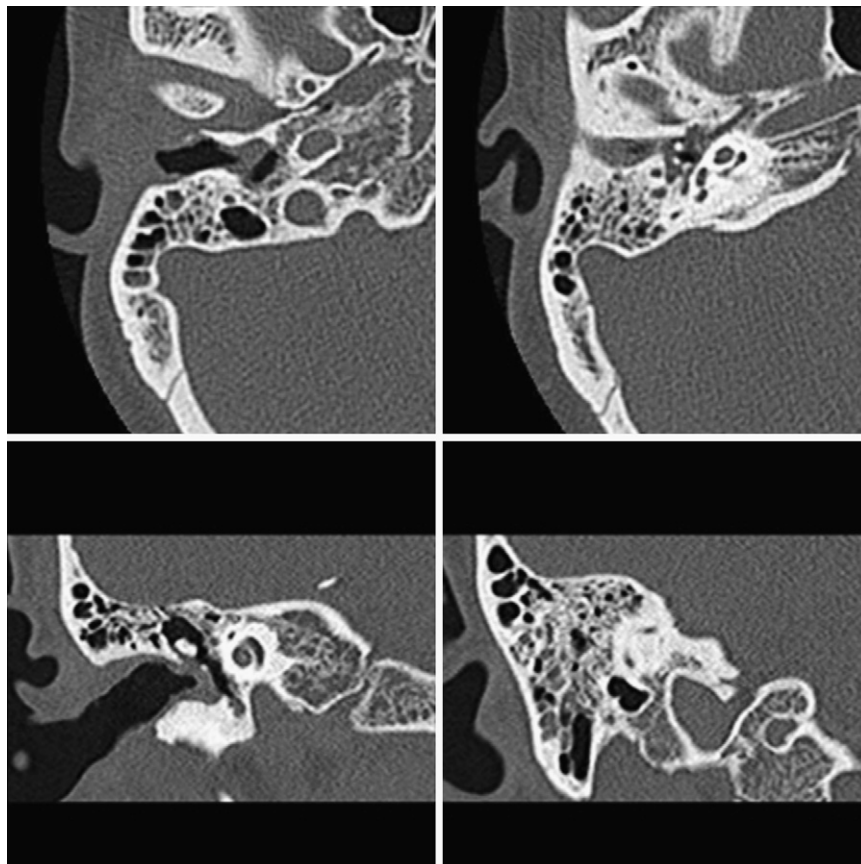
CT scan of the temporal bone showing increased soft tissue in the right middle ear cavity, the external ear canal and the mastoid cavity. CT = computed tomography.
